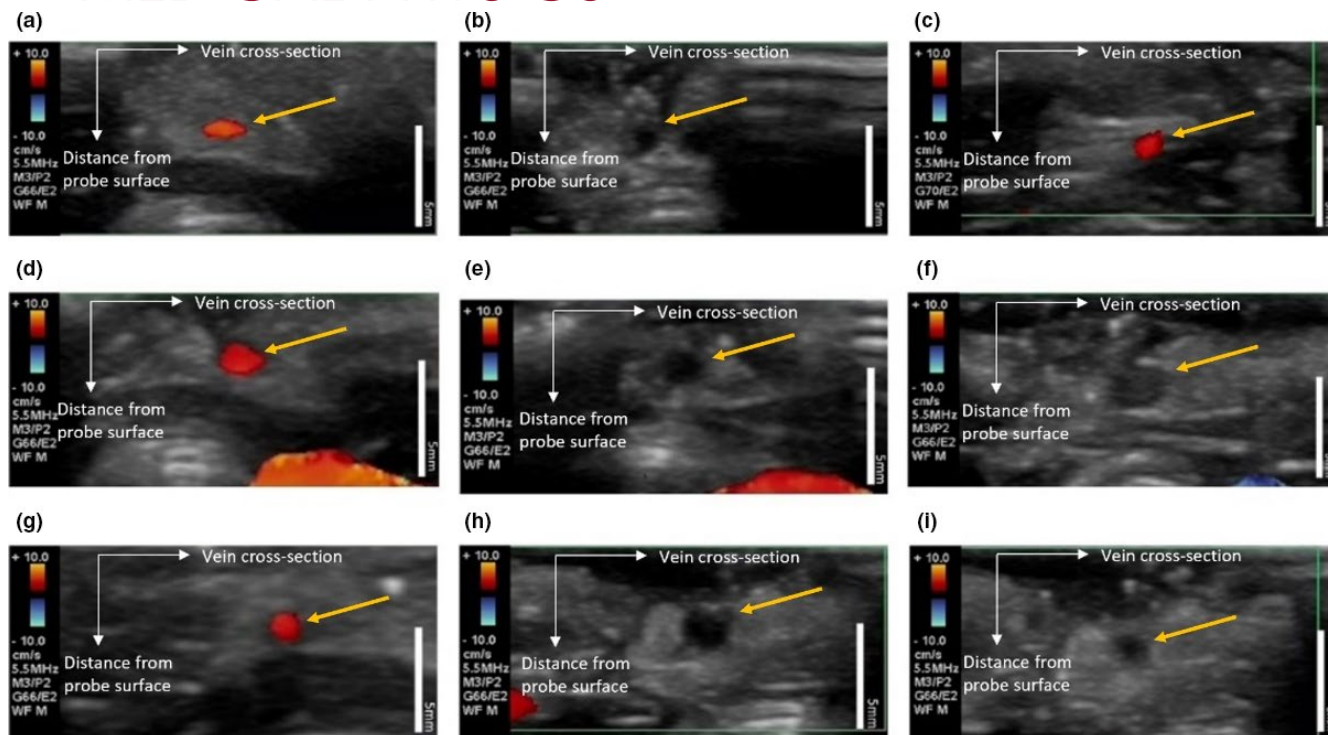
Ultrasound Doppler imaging of the treated jugular vein, jugular vein is marked by arrow. (a), (b), (c) are from rabbit No. 8, which was treated by USELT. (d), (e), (f) are from rabbit No. 5, which was treated by ultrasound only, and (g), (h), (i) are from rabbit No. 6, which was treated by laser only. (a), (d), (g) Ultrasound Doppler imaging before formation of blood clot in jugular vein. (b), (e), (h) Ultrasound Doppler imaging after formation of blood clot. (c) Ultrasound Doppler imaging after treatment with USELT using P- of 1.3 MPa and laser fluence of 8 mJ/cm². (f) Ultrasound Doppler imaging after treatment with ultrasound only using P- of 1.3 MPa. (i) Ultrasound Doppler imaging after treatment with laser only using laser fluence of 8 mJ/cm². P- = peak negative ultrasound pressure. Scale bar = 5mm
